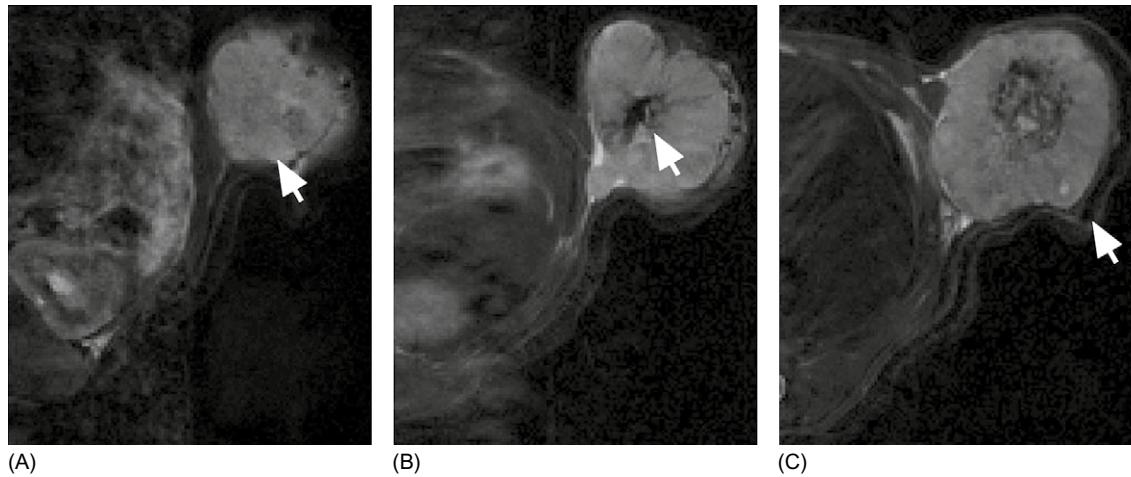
• Serial MR imaging of prostate tumours after intratumoural injection of magnetically labelled NK-92 cells: (A) A pre-injection scan shows the tumour (arrow). (B) A 30-min post-injection scan shows hypodensity suggestive of iron, confirming the delivery of the cells to the tumour parenchyma (arrow). (C) A 24-h post-injection scan shows accumulation of cells at the periphery of the tumour along with residual cells at the site of injection (arrow).
